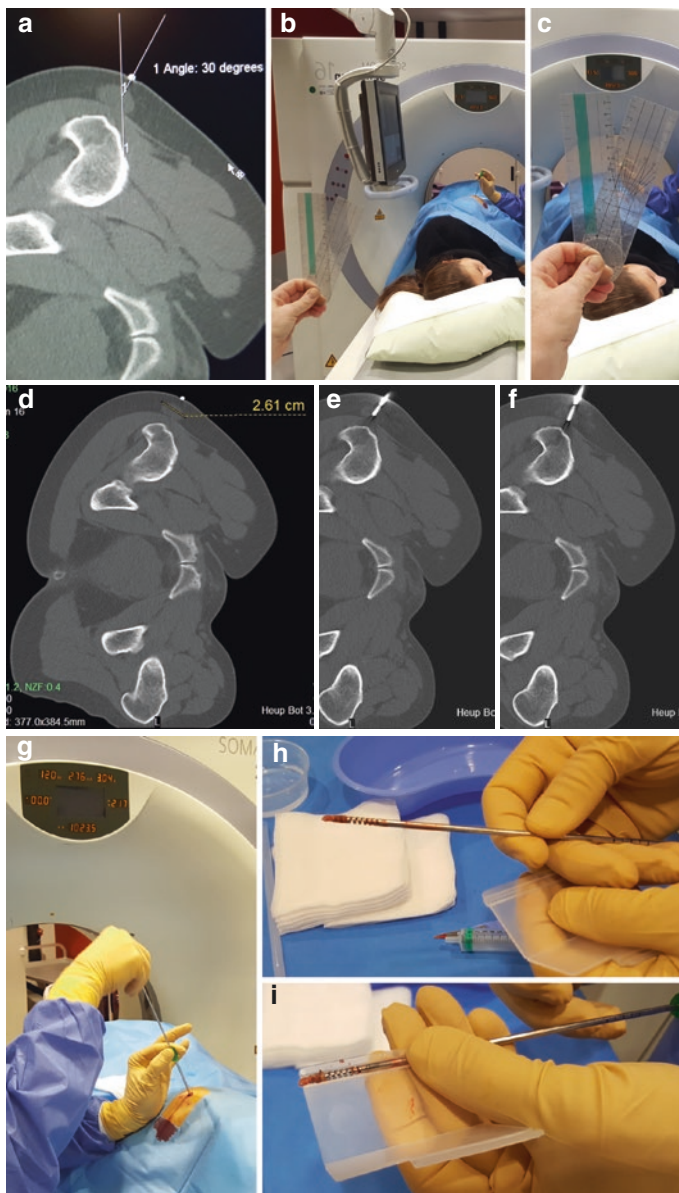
Female patient, 38 years old. Painful mass lesion at the subcutaneous tissue of the left trochanteric area. (a–c) Prebiopsy scan for location and planning of biopsy trajectory and angulation relative to vertical axis (a). Thirty degrees angulation relative to the vertical axis is transferred to the needle using transparent triangle (b, c). (d) Prebiopsy scan with measurement of the thickness of the lesion in the planned axis the biopsy needle. Then positioning of the trocar with cutting cannula in front of the lesion, replacement of the trocar with the receiving needle that includes the helix at the distal 2cm. (e) confirmation of helix position in the lesion before removal of tissue, subsequent CT controlled turning of the biopsy receiving helix into the lesion without transfixation of the lesion. Engravings on the external parts of the needle components are available and are used to control the depth of the needle tip. Then the sample is cutted by turning the cutting cannula over the receiving helix. (f) Second biopsy location using slight different angulation. (g–i) Tissue removal procedure with retraction of the receiving needle (g) and release of the tissue out of the helix with use of pinned plastic needle socket (h, i)
